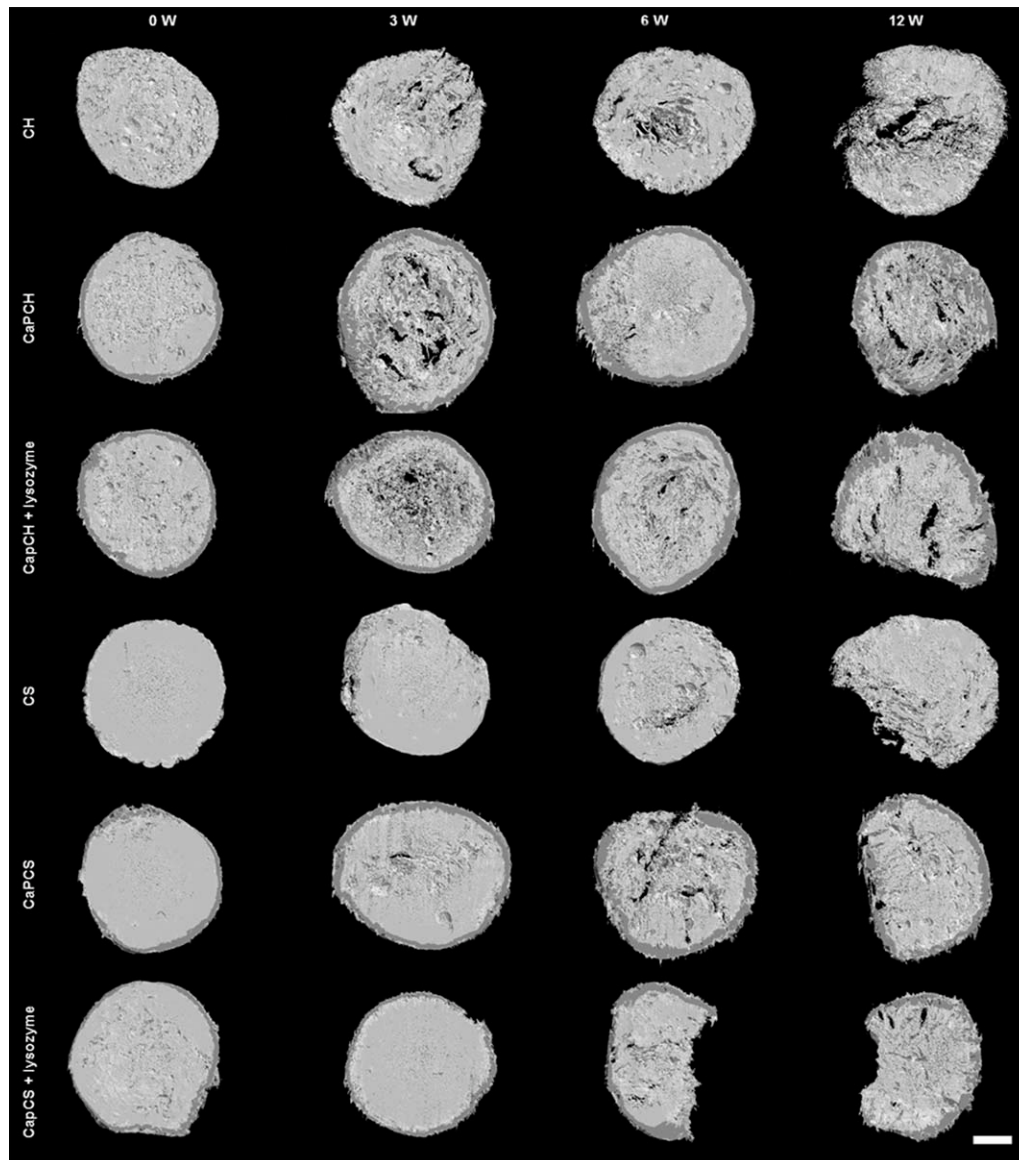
Images of chitosan-based scaffolds obtained by μ -CT: before implantation (week 0 -control) and after 3, 6, and 12 weeks of subcutaneous implantation. The scale bar is 1 mm and applies to all images.
